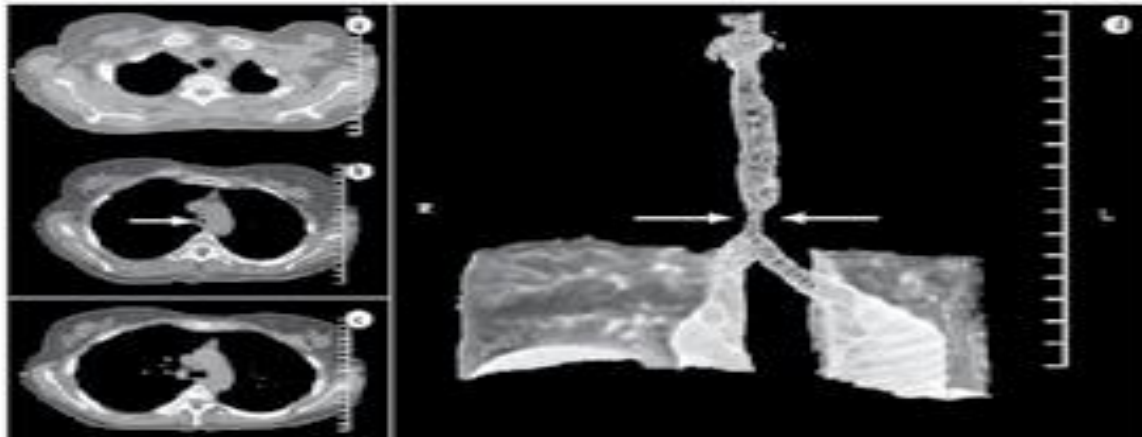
(a, b, c); CT scan of chest; axial slices (d) 3-D rebuilding. White arrows display tracheal stenosis:
